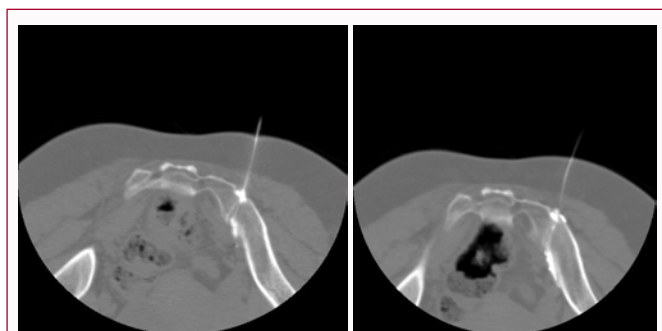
Computed Tomography (CT) guided diagnostic intra-articular injections of bupivacaine.
